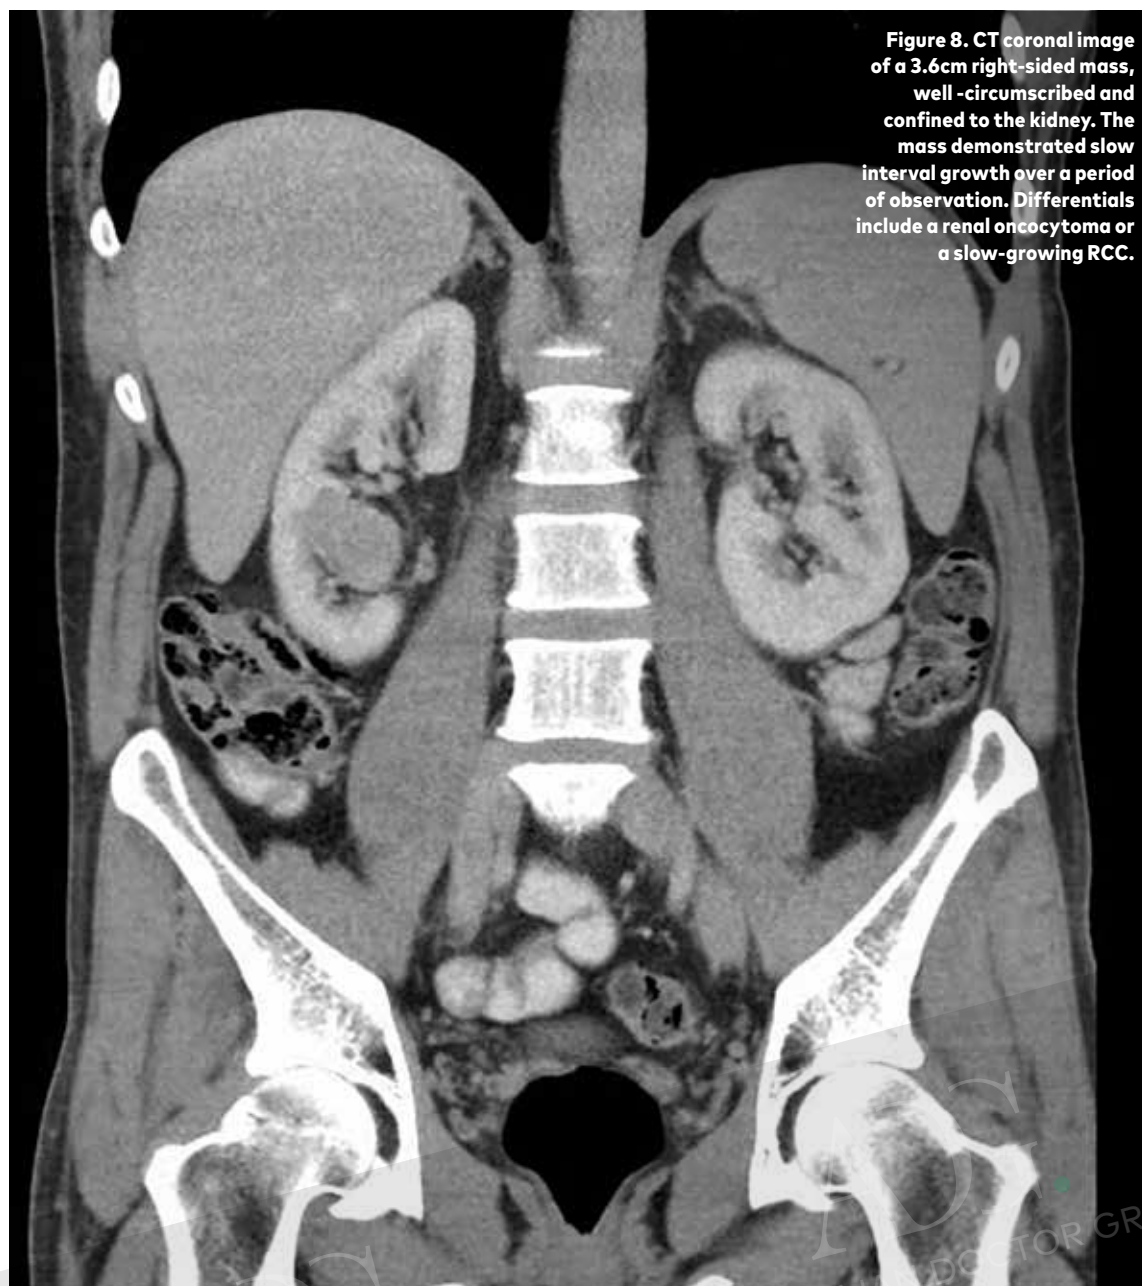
CT coronal image of a 3.6cm right-sided mass, well-circumscribed and confined to the kidney. The mass demonstrated slow interval growth over a period of observation. Differentials include a renal oncocytoma or a slow-growing RCC.
